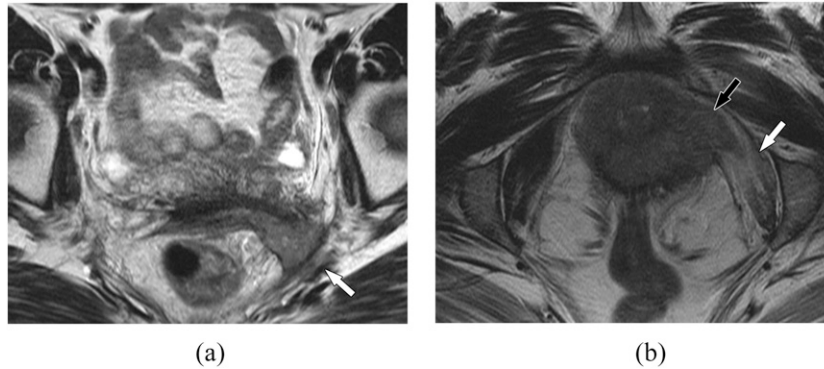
Vaginal cancer, pelvic sidewall involvement. (a) A 45-year-old female with Stage III vaginal cancer. Axial T_2 weighted MR image shows infiltrative mass at the vaginal fornix extending into the left pelvic sidewall (white arrow), involving the piriformis and the sciatic region. Biopsy confirmed poorly differentiated squamous cell carcinoma. (b) A 53-year-old female with Stage IV vaginal cancer. Axial T_2 weighted MR image shows infiltrative vaginal mass extending into the left pelvic sidewall (black arrow). Note the T_2 hyperintensity reflecting oedema within the obturator internus muscle (white arrow). Urethral involvement in this patient, however, established Stage IV disease.
